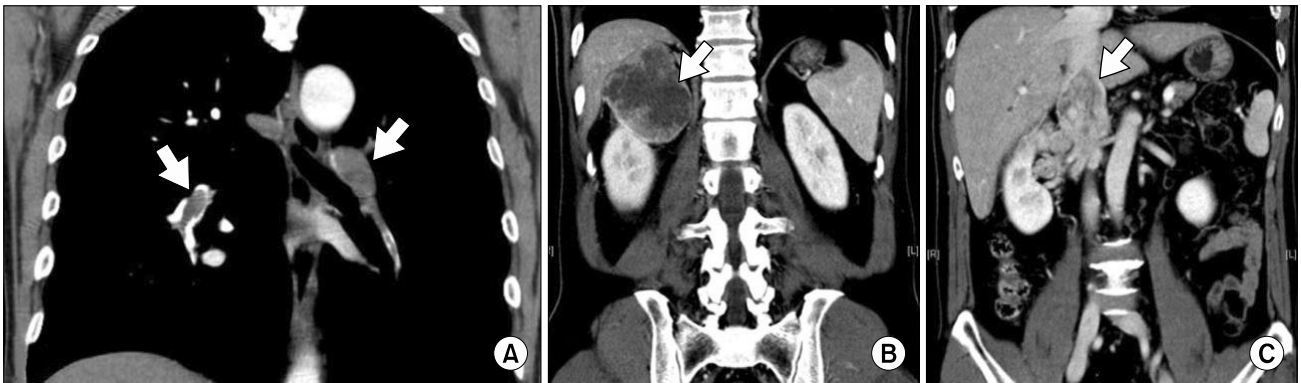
(A) Chest computed tomography shows filling defects in the pulmonary arteries, characteristic of pulmonary embolism. (B) A large mass in the upper pole of right kidney. (C) The thrombus is detected as a hypodense filling defect within the contrast enhanced inferior vena cava.
